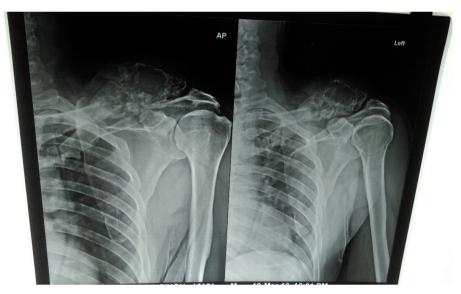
X-ray showing expansile radiolucent lesion arising from lateral end of left clavicle.
